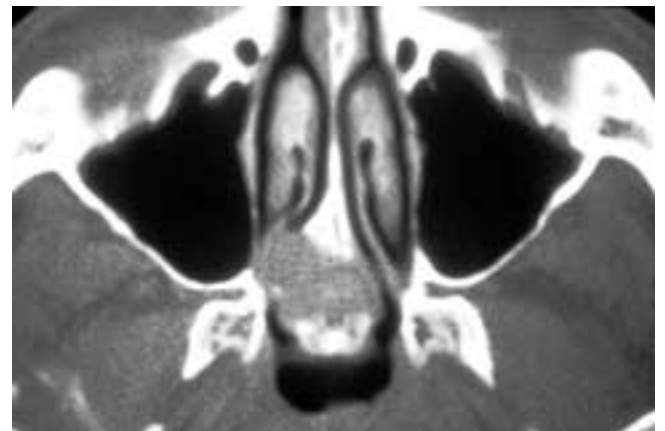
Axial CT scan shows an expansile, partially calcified mass in the posterior nasal septum. This patient had an osteochondroma.
